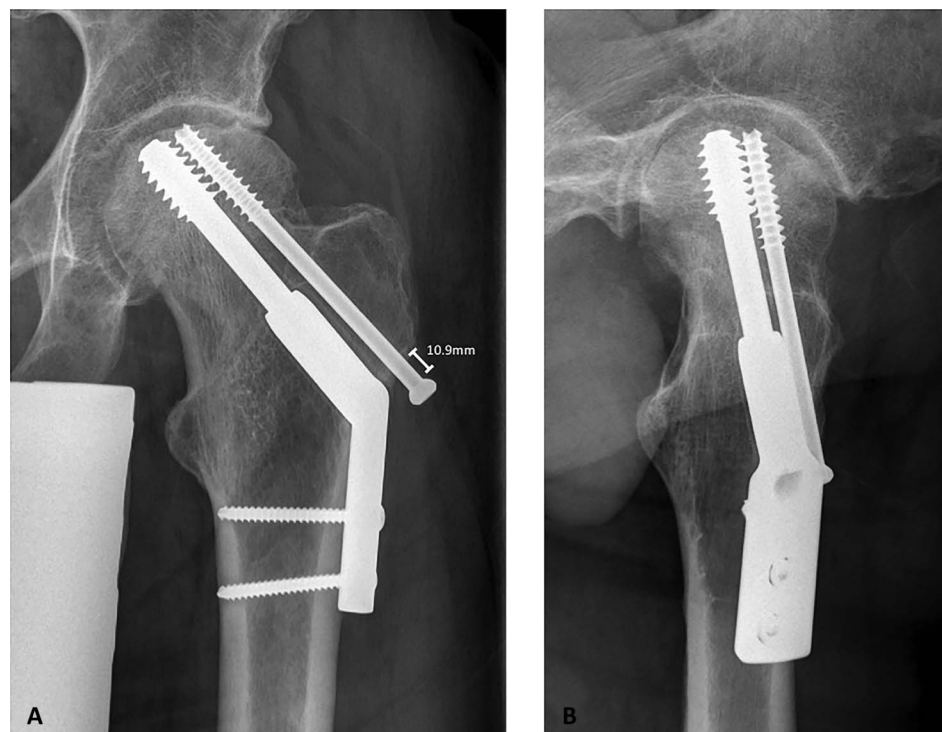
Anteroposterior (A) and lateral (B) radiographs at 18 months of follow-up showing 10.9 mm shortening. Of note, this patient concomitantly developed avascular necrosis of the femoral head.
